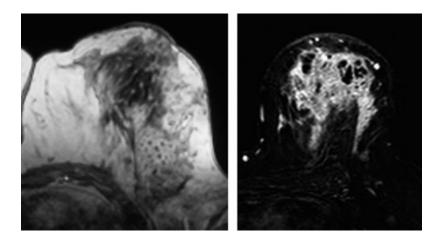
Magnetic resonance images showing increased periareolar thickness, microabscess focuses in outer quadrant and parencyhmal contrast enhancement indicating diffused inflammation in patients with Idiopathic Granulomatous Mastitis (IGM).
